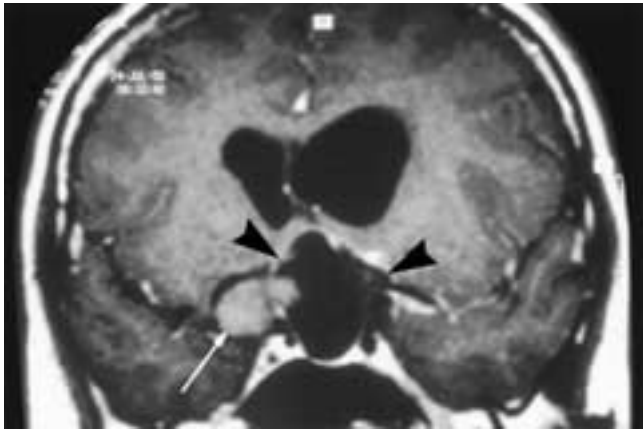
Cyst of Rathke's pouch. Contrast-enhanced coronal T1-weighted image shows a multilobulated intra- and suprasellar cystic mass (arrowheads) with one component (arrow) isointense to brain. There is no enhancement of the mass. The chiasm was compressed. Hydrocephalus is present.
